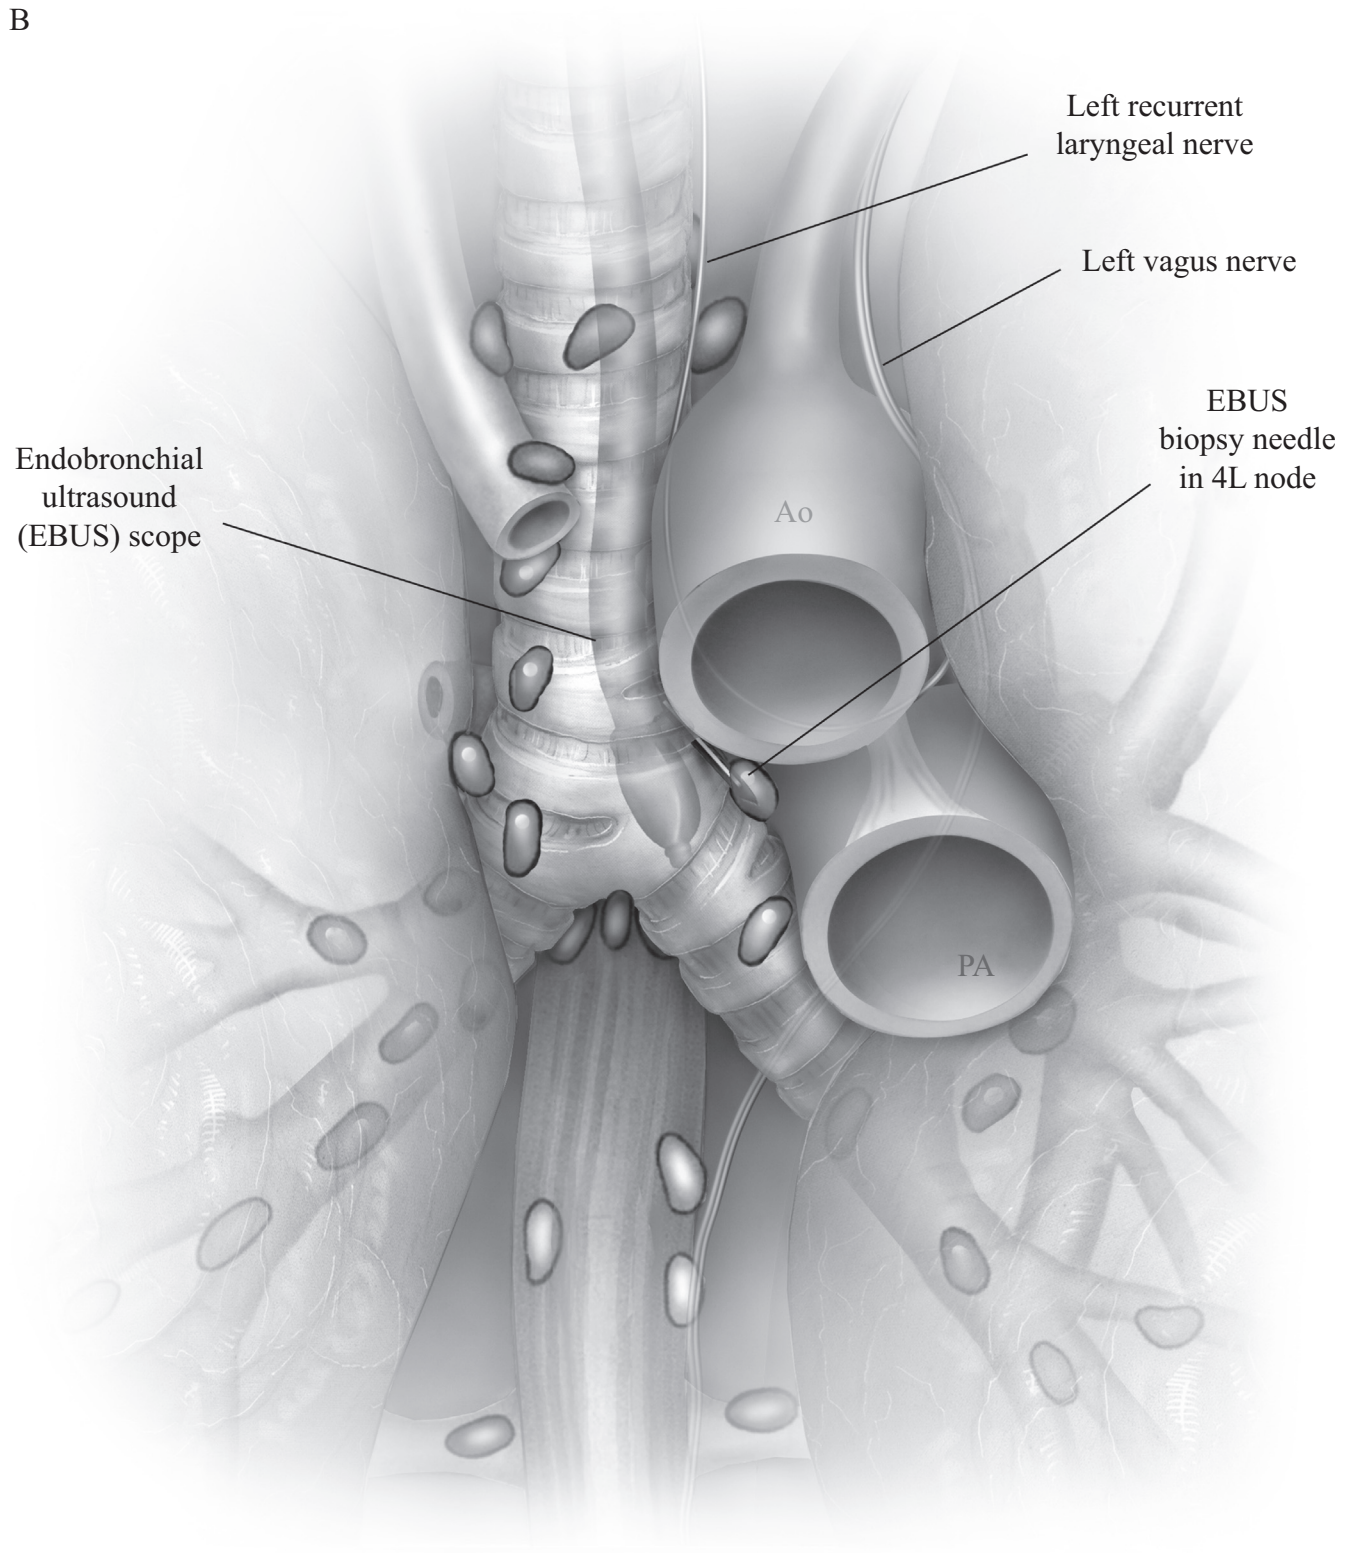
(Continued) (B and C) Staging includes a positron emission tomography scan and mediastinal staging. Mediastinum can be staged via endobronchial ultrasound (B).
